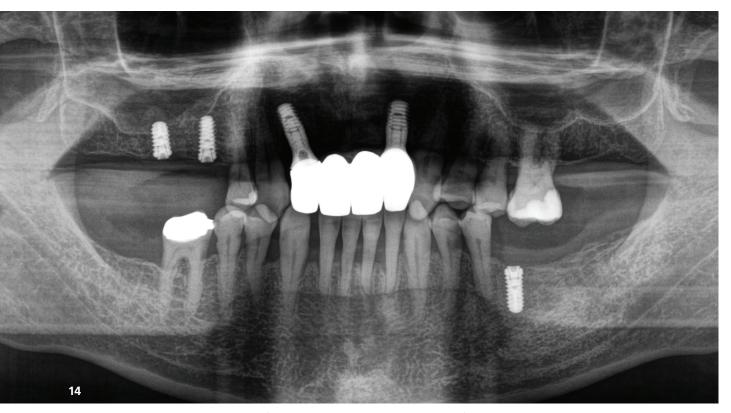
Panoramic radiograph. Control 3 years after prosthetic restoration, Stable periodontal findings. Further implants have been placed in the posterior region.
